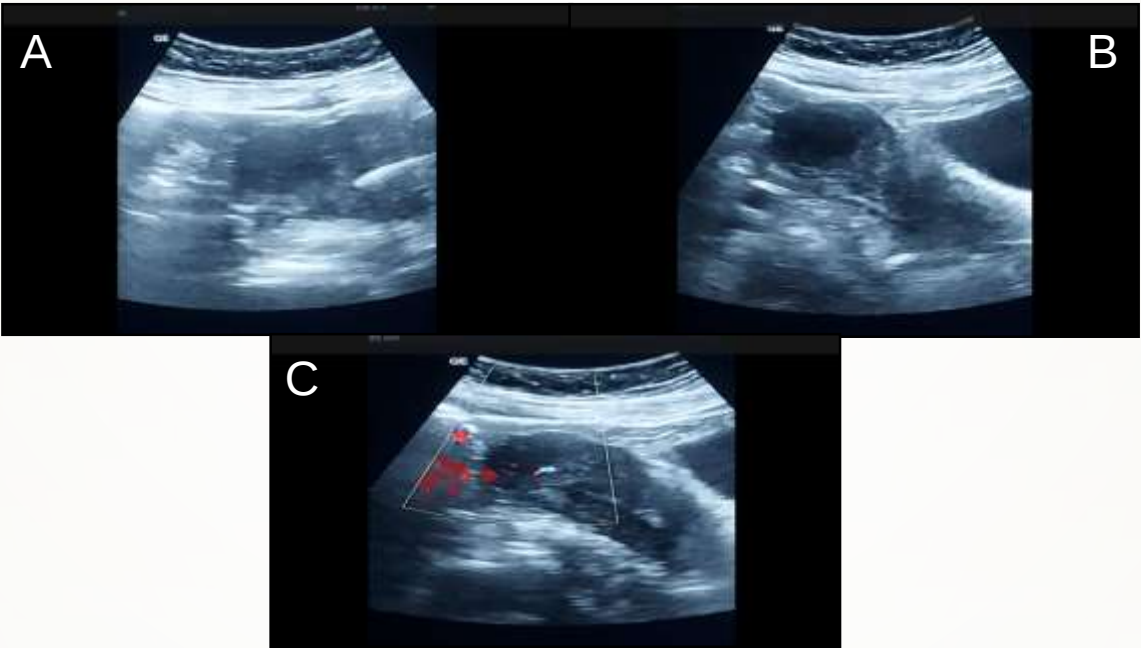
A 32 year old female patient presenting with history of anaemia with no abnormal vaginal bleeding. A) Transabdominal gray-scale US transverse view shows a well defined hypoechoic subserosal fundal lesion. B) Transabdominal gray-scale US longitudinal view depicts the lesion as a fundal subserosal uterine fibroid which was misinterpreted as a right adnexal mass, however accurate ultrasonographic assessment confirmed being a subserosal fibroid mass which shows positive doppler flow signal in (C).
